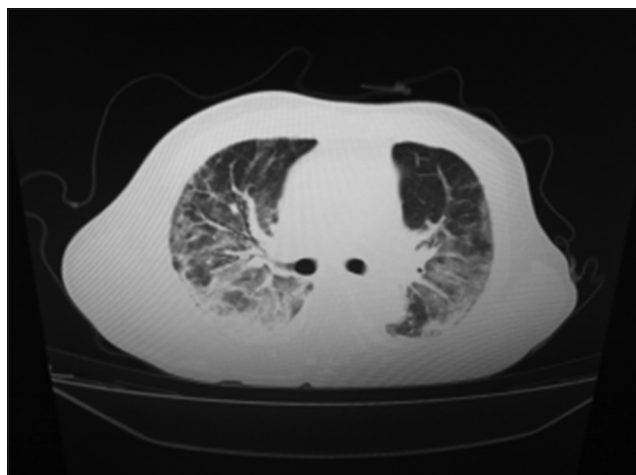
Chest computed tomography image of the patient before consultation (February 24)
